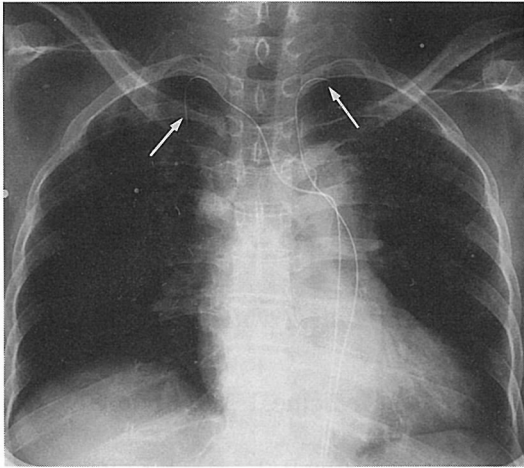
B, Chest radiography shows two catheters (arrow) indwelled at each internal thoracic artery for intraarterial chemotherapy.
